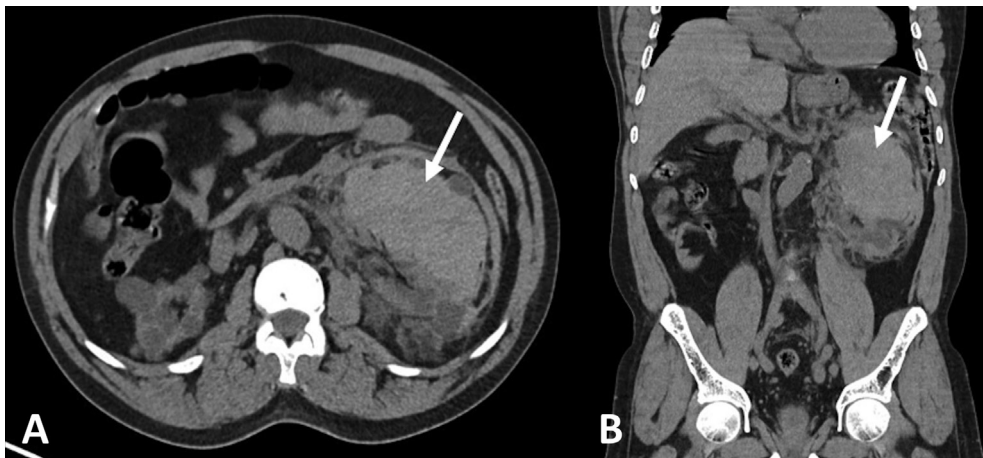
Contrast-enhanced CT showing left renal and perirenal hematoma (white arrows). A – axial view; B – coronal reconstruction.
